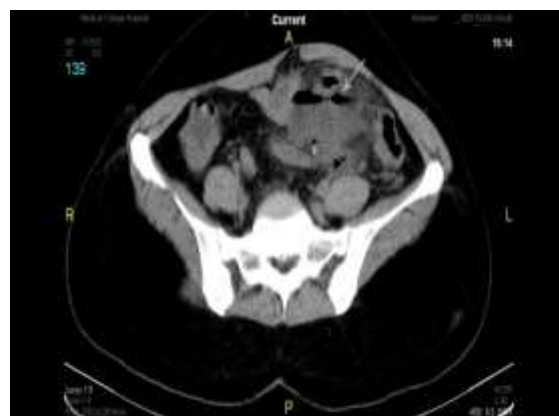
The CT findings in complicated diverticulitis may include the presence of an abscess (long arrow), contained or free extraluminal air pockets (short arrow), with descending colon wall thickening
